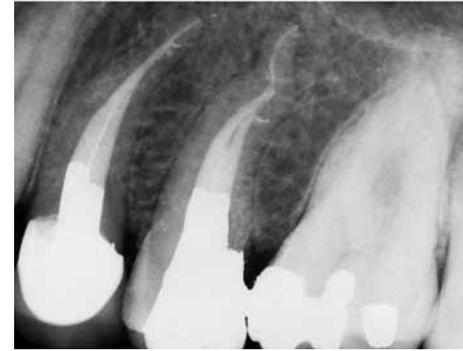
Postoperative radiograph of an upper second bicuspid with two canals. The canals were prepared with files X1 and X2 prototypes in the apical half. The coronal half was enlarged with the X3 and X4 in a step-back modality. The canals were obturated using Schilder technique or warm gutta percha (Dr. Michael Scianamblo, San Rafael, California)
